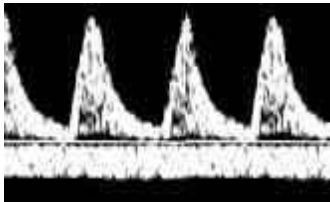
The Site of the Doppler Study of the Uterine Artery is just Cranial to the Crossing of the External Iliac Artery<sup>15</sup>
